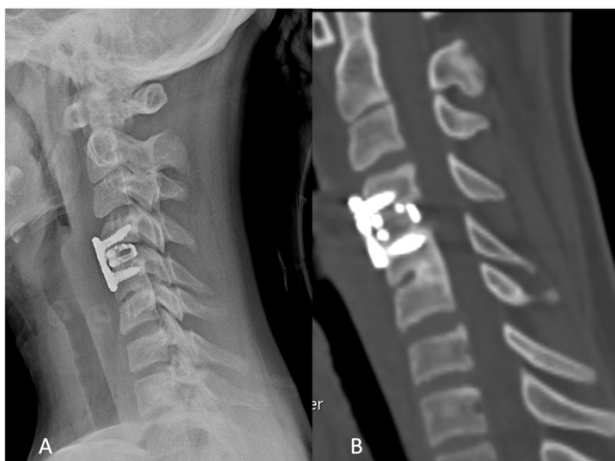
Postoperative imaging. A): Postoperative lateral X-Ray (A) and sagittal CT-scan (B) showing C4-C5 interbody fusion and anterior plating.
